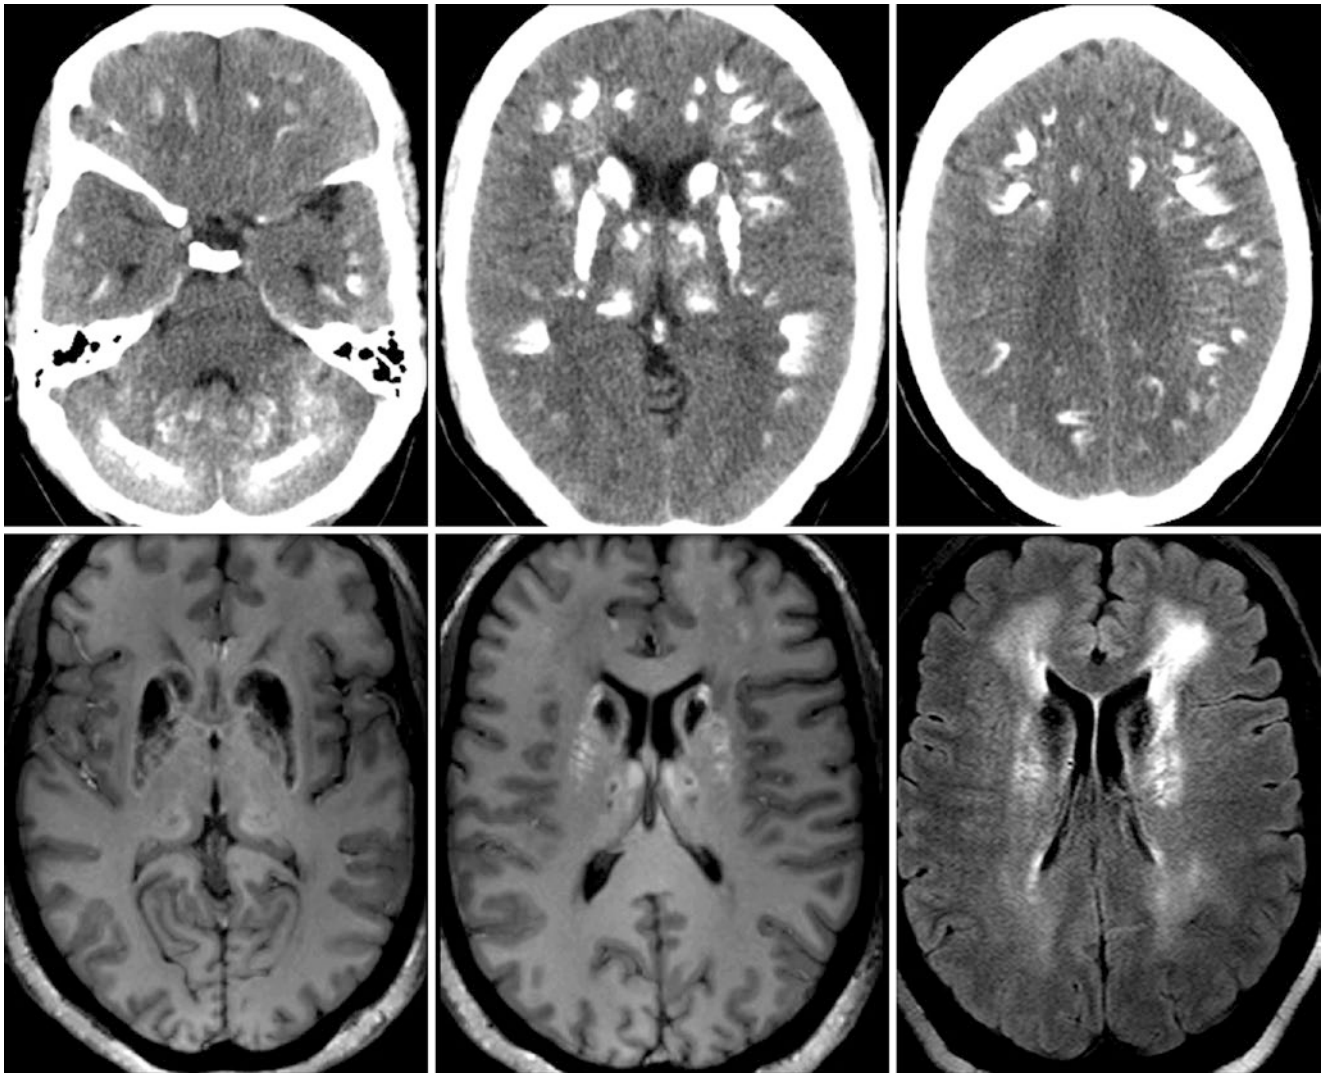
Comparison case of Fahr disease. A 52-year-old female had diffuse, severe BG calcifications on a NECT (*top row*), which also involved the cerebral and cerebellar subcortical and deep white matter. On a 3T MRI with GE T1WI (*bottom left and middle*), the heavily
